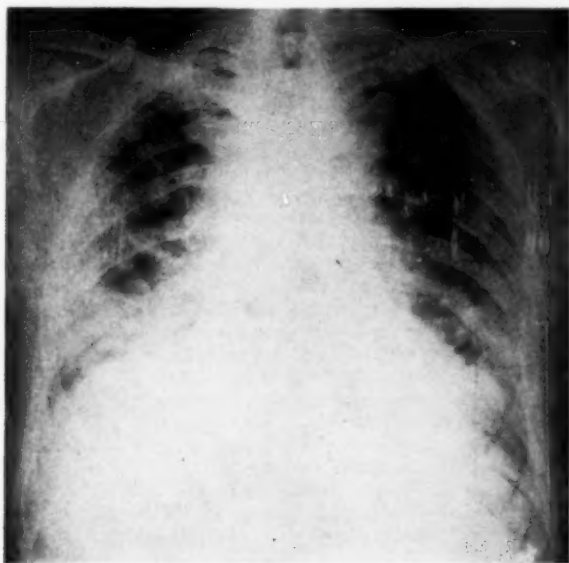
Roentgenograph of lungs showing diffuse reticular changes.
